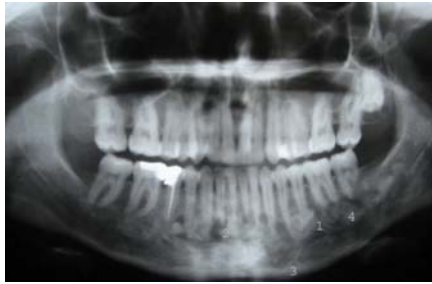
Panoramic radiograph taken at the postoperative 2nd year.
